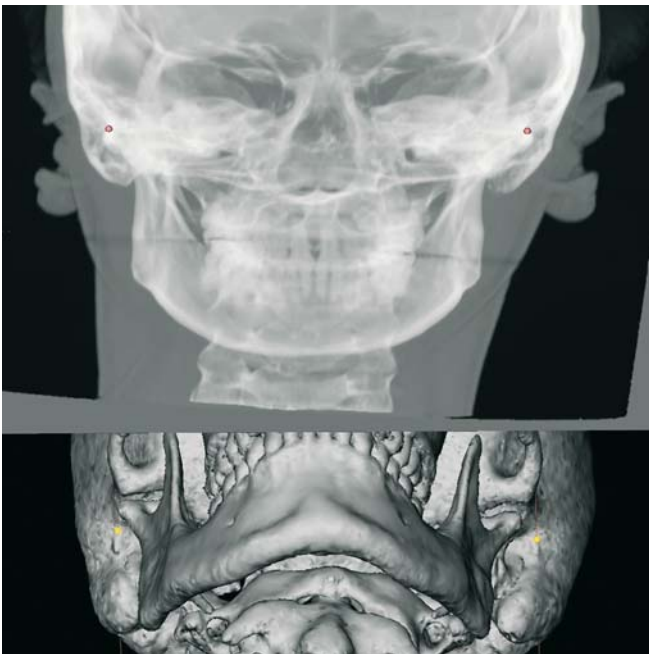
Porion. Virtual frontal cephalogram linked to the 3-D hard tissue surface representation (3-D CT, patient K.C.) allows verification of the transversal position of the Porion landmarks
